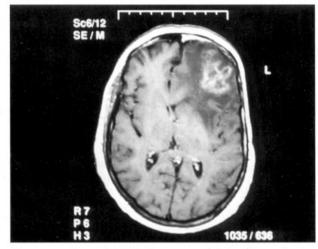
Cranial MRI demonstrated a dense lesion compressed the left ventricle
